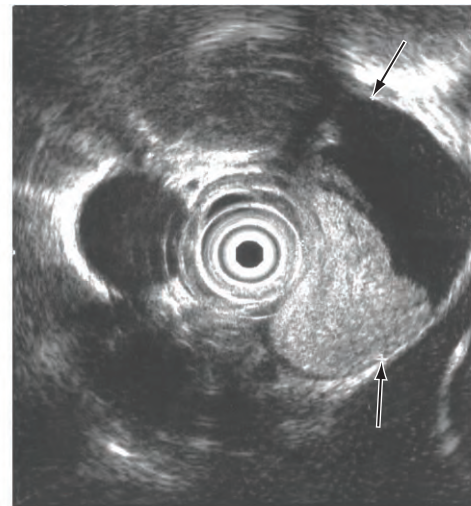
Foregut cyst. *Upper*, Endoscopic ultrasound demonstrates a mass (*arrows*) adjacent to the trachea and esophagus. The cyst has two components, one hyperechoic (white), representing proteinaceous material, and one hypoechoic (black), representing fluid. *Lower*, A foregut cyst in close proximity to the esophagus and trachea.
